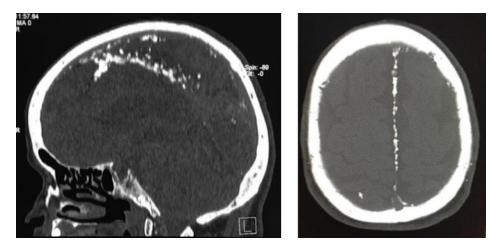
Sagittal and axial views of the bone window of Cranial CT showing dense intracranial calcifications along the falx cerebri and tentorium cerebelli hyperostosis of the skull and thickened cranium.
